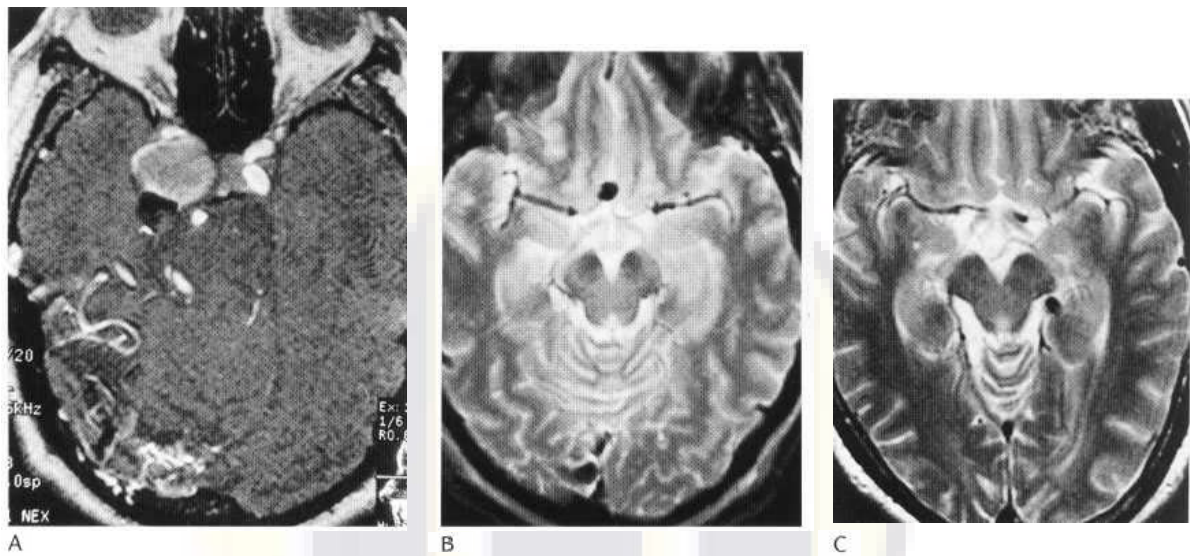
(A) MRA axial study. Large aneurysm of the right carotid artery bifurcation is shown protruding up from the right cavernous sinus. There is also a small occipital angioma supplied by the right posterior cerebral artery. (B) Axial T₂-weighted MR image showing a small anterior communicating artery aneurysm. (C) Axial T₂-weighted MR showing a small aneurysm of the distal left posterior cerebral artery.
